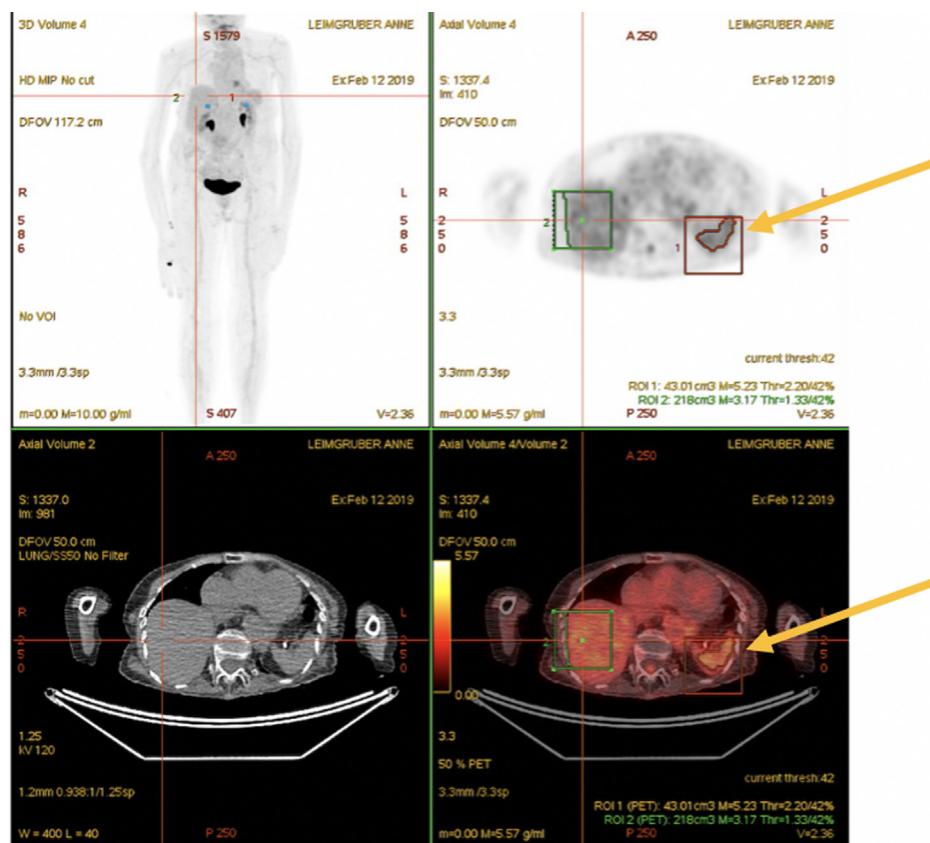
Diffuse splenic uptake on positron emission tomography/computed tomography. Yellow arrows show the diffuse uptake of the spleen. The red box indicates the measurement of diffuse splenic uptake, relative to the liver (green box).
